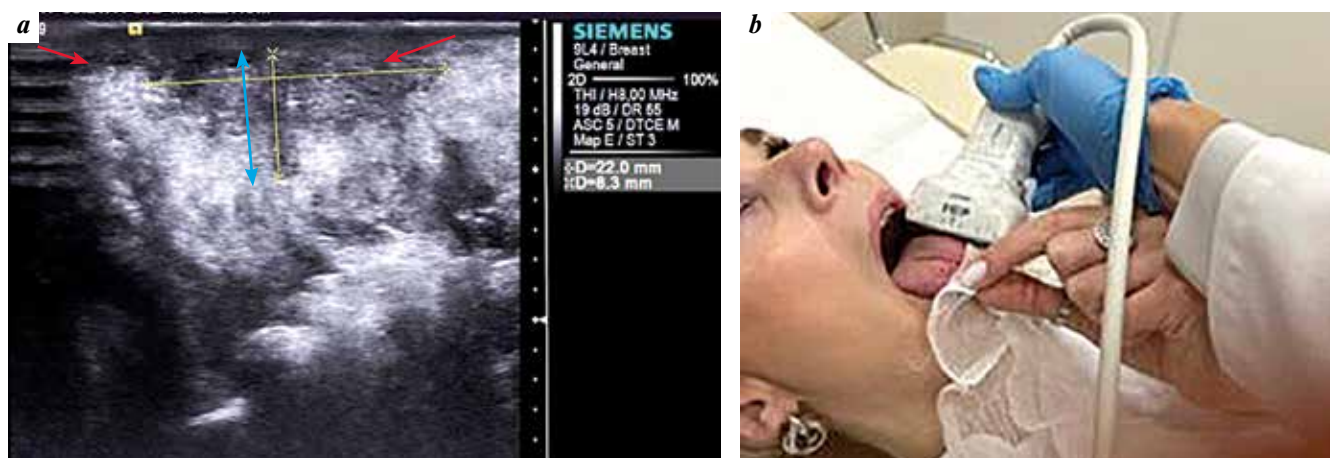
Intraoral ultrasonography of the tongue (longitudinal scanning): *a* – echogram of moderately differentiated squamous cell carcinoma of the lateral surface of the tongue (indicated by red arrows), tumor thickness 8.3 mm (indicated by blue arrow), T2 (TNM); *b* – longitudinal scanning with linear probe in the frequency range 4–9 MHz
